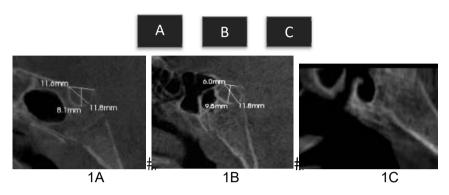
Sagittal view of CBCT image
